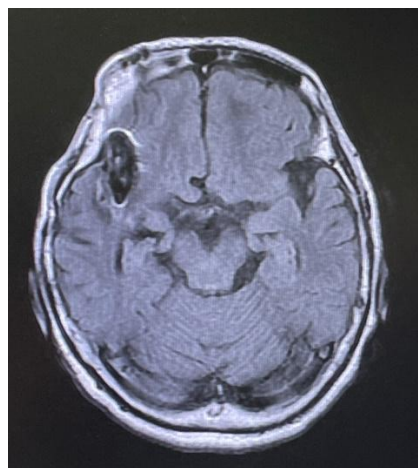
Brain magnetic resonance imaging. Post-surgical changes secondary to the subarachnoid hemorrhage repair are observed. No cerebrovascular lesions, edema, or hematomas are noted. Due to a clip, there are artifacts around the right Sylvian fissure.
